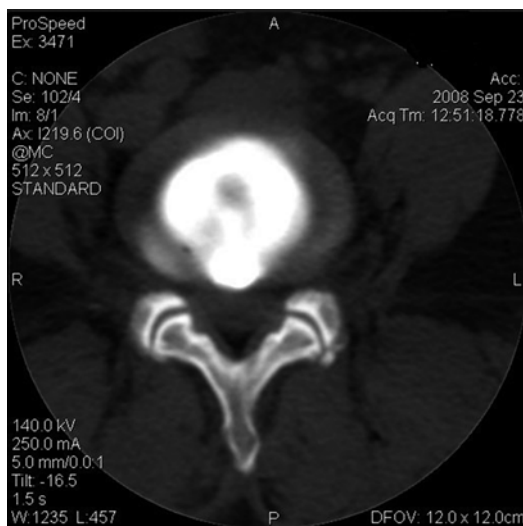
Axial post-diskography CT scan with grade 3 annular tear. Contrast extends posteriorly to the outer annulus within a contained protrusion
